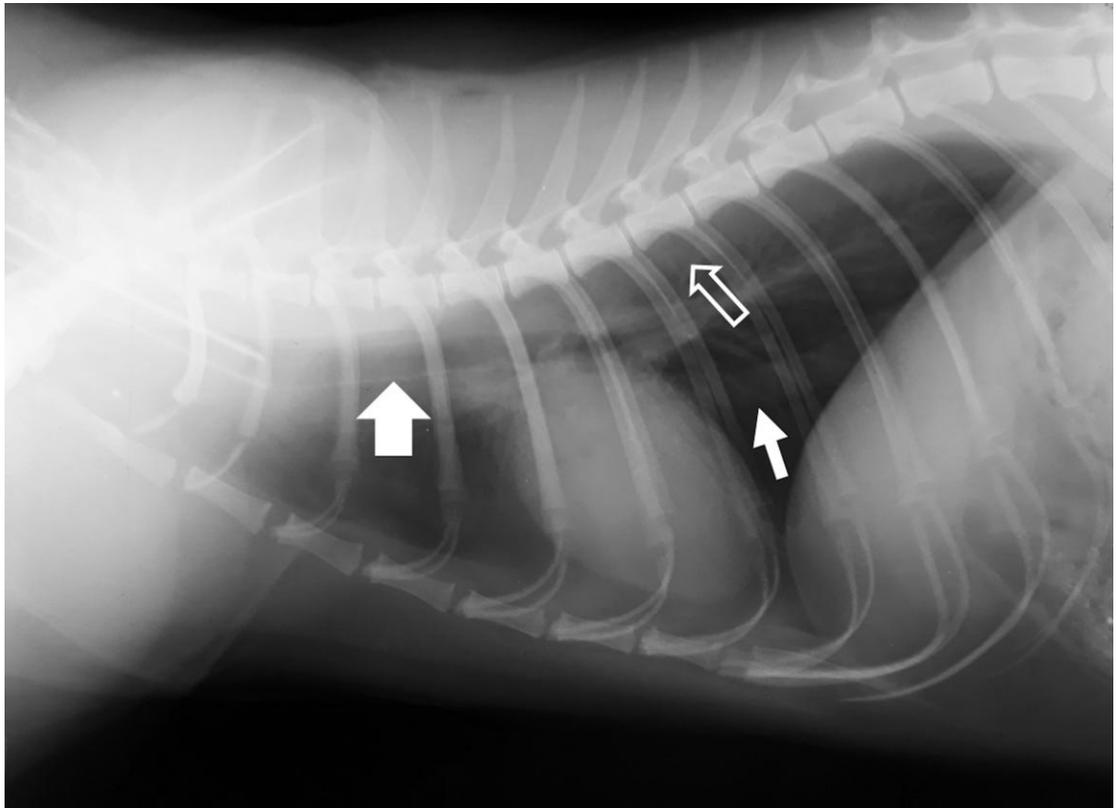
Right lateral (RL) thoracic radiograph of caracal II at the age of 1.2 years. The thoracic spine consists of 13 thoracic vertebrae with relatively long spinous processes. Pairs of ribs are 13 with the last pair floating. The sternum is fairly straight sloping from cranial to caudal and consists of six sternbrae, manubrium sterni and xiphoid process. The cardiac silhouette is not in contact with the diaphragm. The carina is seen at the level of the sixth rib. The trachea, descending aorta and caudal vena cava are indicated by a thick white arrow, open white arrow and thin white arrow, respectively.
